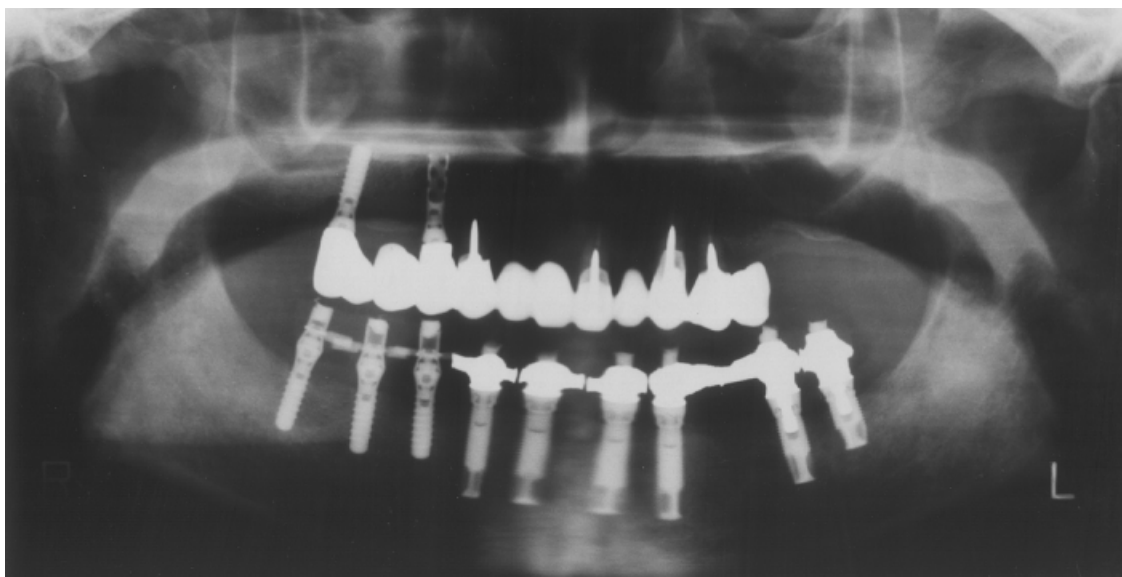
Radiograph of a patient with multiple implants in the posterior region of the mental foramen. Since the multiple implants in the posterior region could support a larger load, they might reduce the deformation of the mandible.
